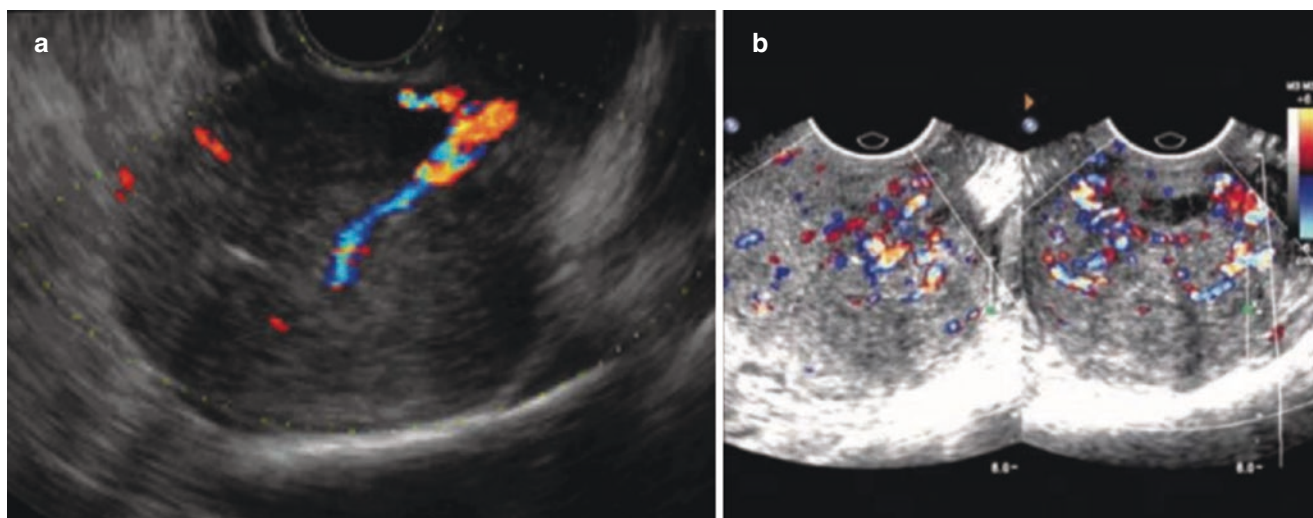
Adenomyosis (VI). (a-b) The blood flow in the focus of adenomyosis is sporadic and stellate distributed by Color Doppler
